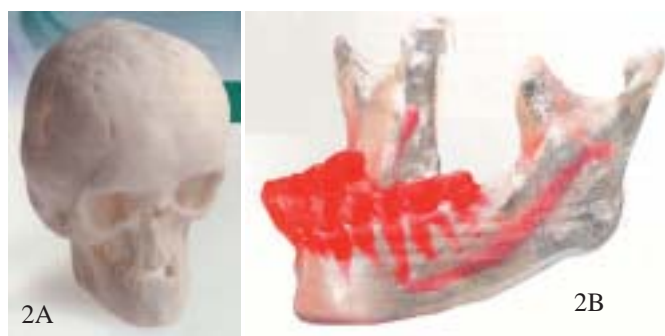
3D Models created out of CT images. A) Craniofacial complex printed in RapidView® mode, B) model of the Mandible printed in ClearView® mode showing the use of stereolithography (courtesy of Medical Modeling LLC - Golden - Co, USA).
